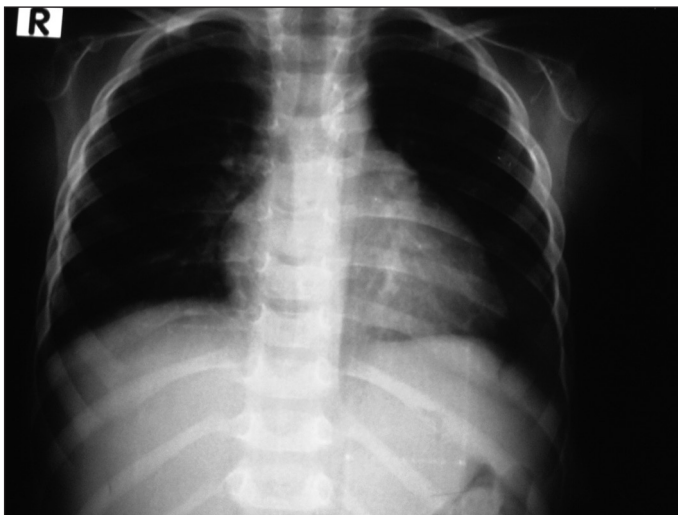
X-Ray after transfusion.
